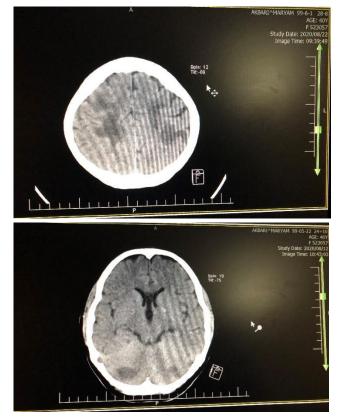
Spiral Brain CT scan without contrast.
